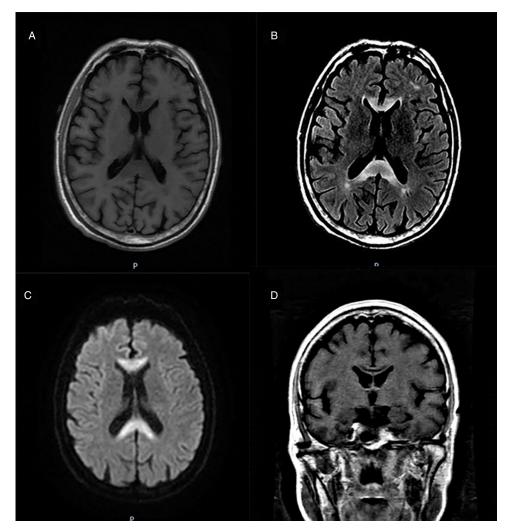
The typical MRI findings of alcoholic MBD patients. The MRI images reveal high signal intensities of the corpus callosum lesions on DWI and T2-weighted images (\boldsymbol{b} , \boldsymbol{c}). The lesions in the corpus callosum appear as regions of low signal intensity on T1-weighted images (\boldsymbol{a}), with the lowest signal intensity in the middle layer, presenting the "sandwich sign" (d); and no enhancement is observed in the corpus callosum lesions (\boldsymbol{d}).
